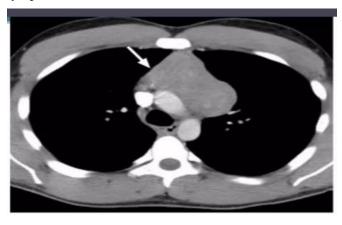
PET CT showing anterior mediastional mass measuring 13.4 x 12.5 x 8 cm.
